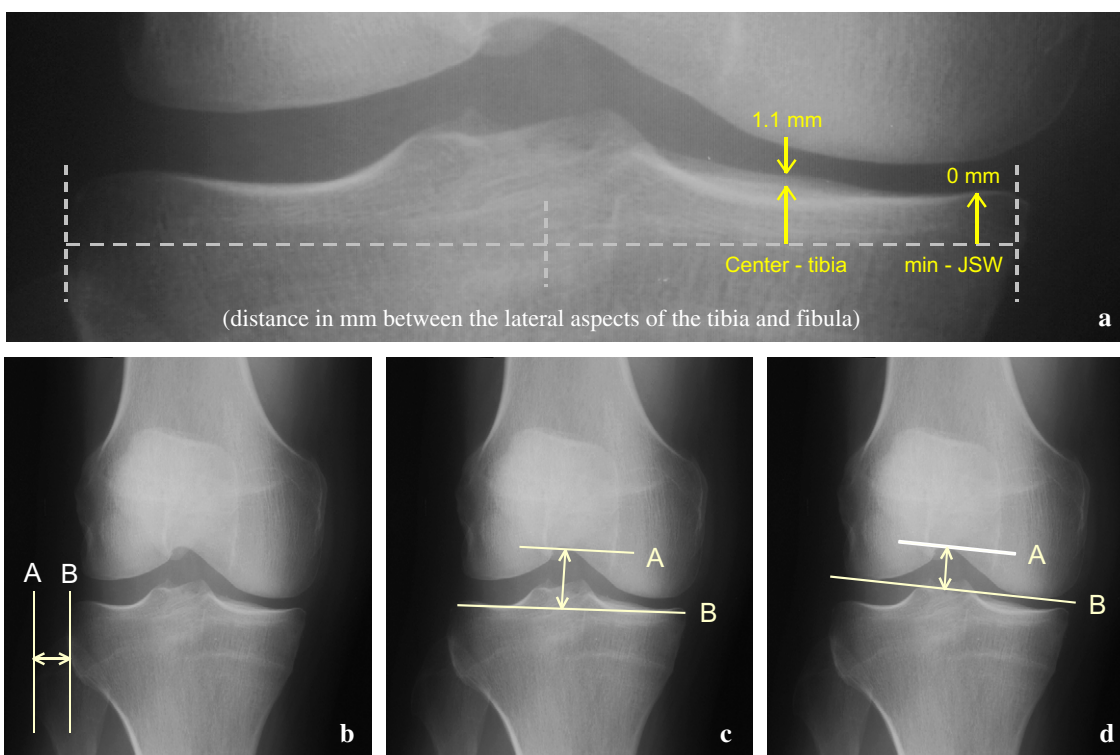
Radioanatomic positioning markers. (a) Alignment of the medial tibial plateau and X-ray beam: The degree of alignment of the medial tibial plateau and central X-ray beam was expressed as the distance between the anterior and posterior margins of the medial tibial plateau. The IMD was measured both at the midpoint of the medial compartment and at the point at which medial JSW appeared narrowest. (b) Knee rotation: Knee rotation was measured as the shortest distance, in mm, between parallel lines drawn tangent to the lateral aspects of the tibia and head of the fibula. (c and d) Femerotibial angle: The marker of the femerotibial angle was the height of the femoral notch. Two estimates of the height of the notch were examined: one relative to a line drawn tangent to the nadirs of the medial and lateral tibial plateau (c), the other relative to a line drawn tangent to the medial and lateral femoral condyles (d).
